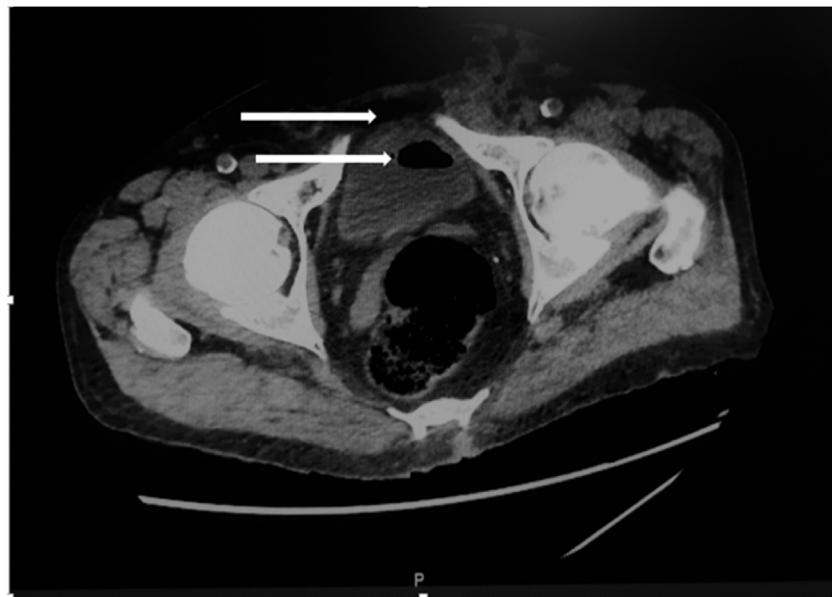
abdominal CT scan showed pelvic air and fluid collection and air in the bladder.
